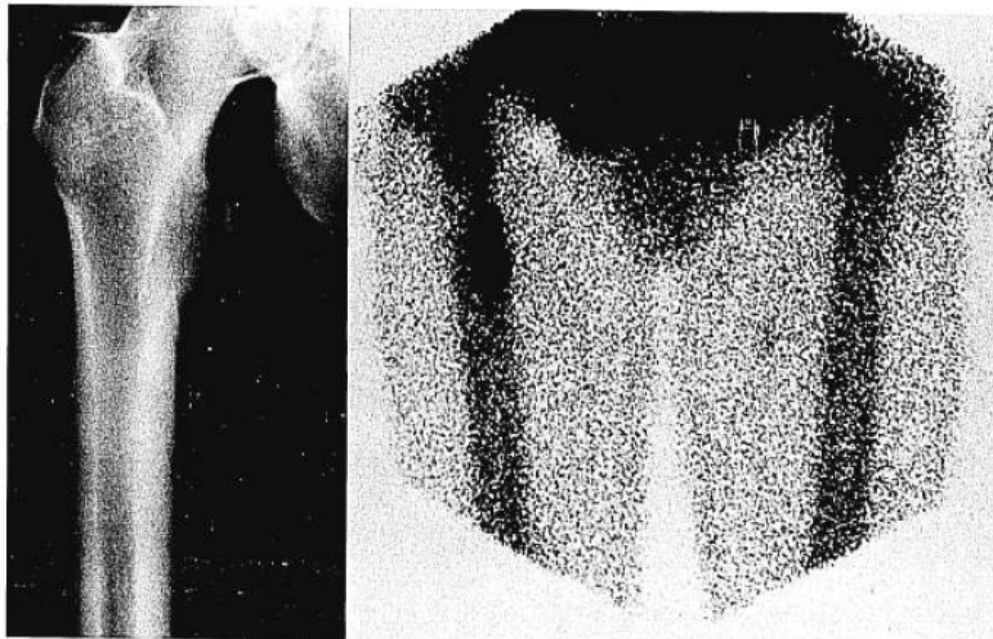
(Patient 12) (Left) Anteroposterior roentgenogram of right femur shows stress fracture just below lesser trochanter on medial side. (Right) Scintiscan of both proximal femurs shows increased tracer activity at fracture site.
